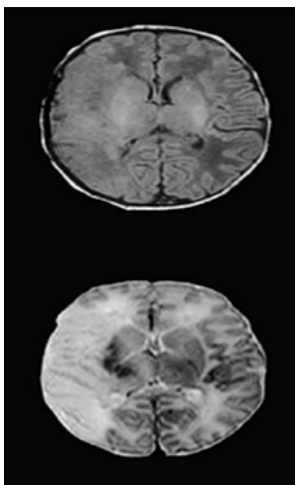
MRI Brain on day 3 of life.
